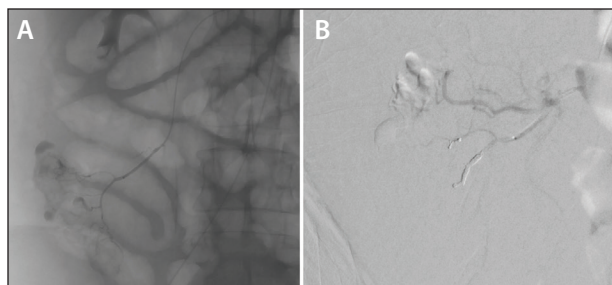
A patient with decompensated alcohol-induced cirrhosis and concurrent coagulopathy presented with massive lower gastrointestinal bleeding. CTA demonstrated arterial extravasation from the ileocolic arterial distribution. Angiography showed localized bleeding from two terminal branches of the ileocolic artery (A). Angiography after embolization with 2-mm low-profile hydrocoils showed dense coil packs with cessation of bleeding (B).
